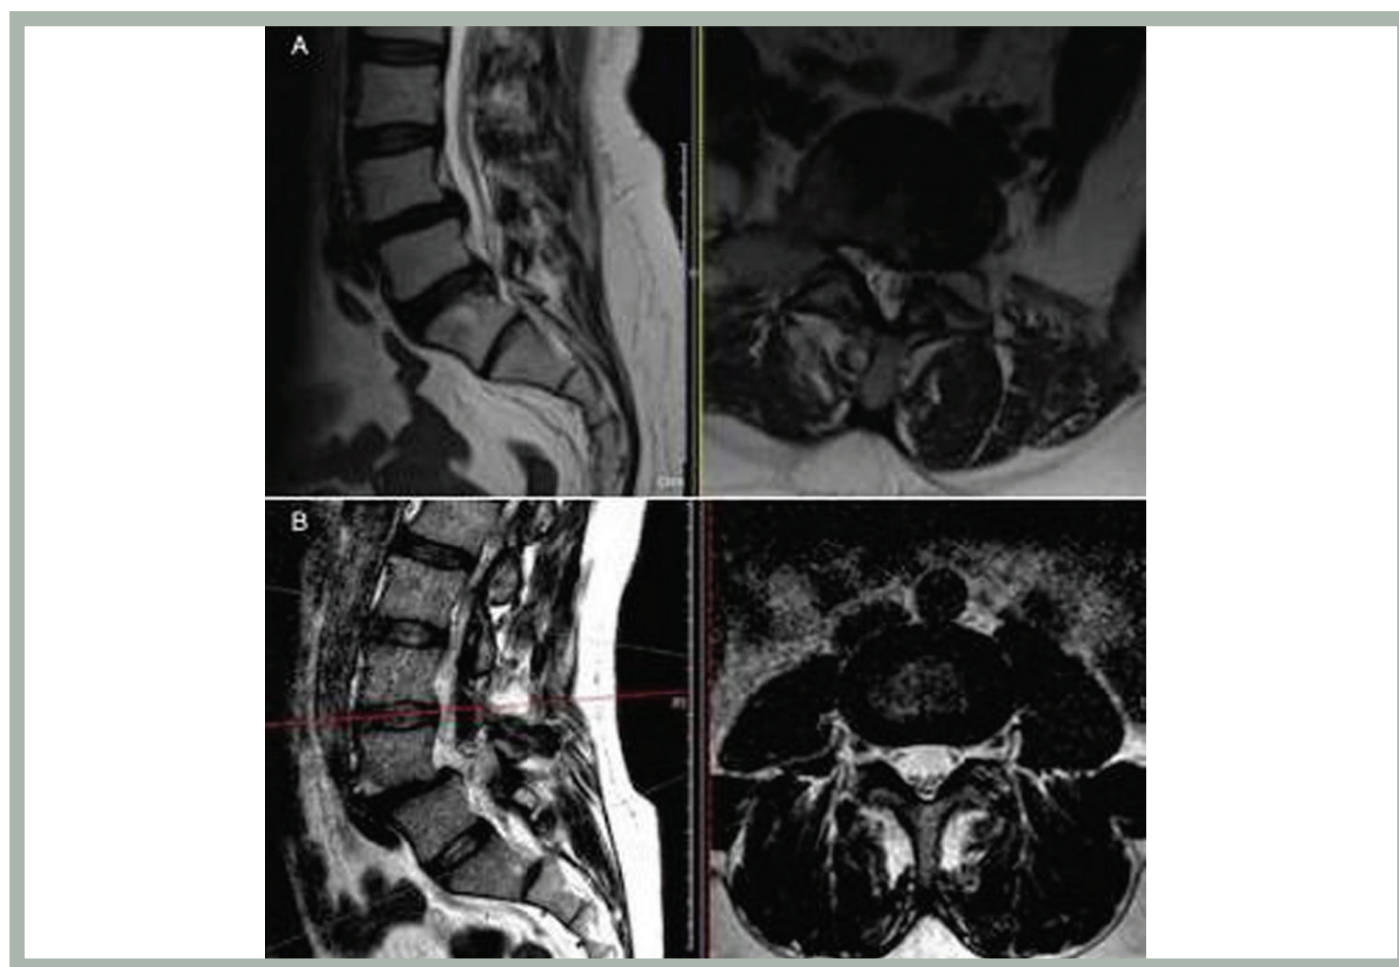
Upper figures (A): T2-weighted MRI in a patient with degenerative spondylolisthesis showing grade 4 disc herniation in the adjacent segment. Lower figures (B): T2-weighted MRI in a patient with isthmic spondylolisthesis showing no disc herniation in the adjacent segment
